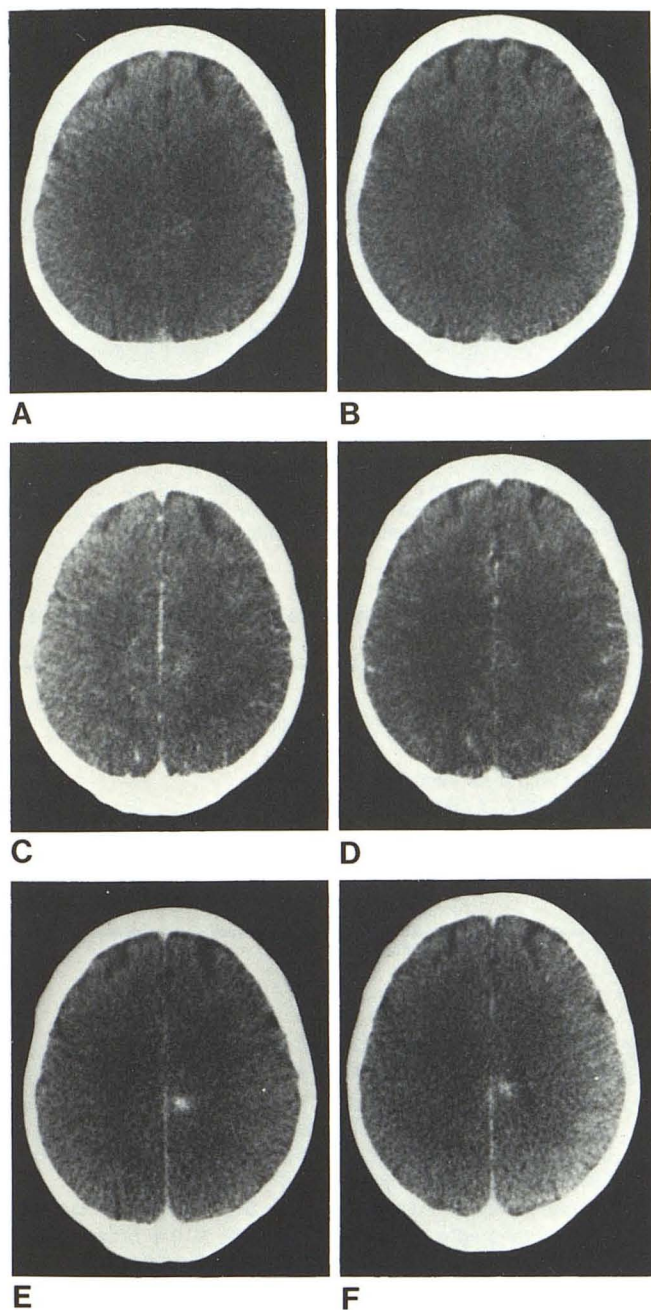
Category 2 lesion. Normal precontrast (A and B) and immediate (C and D) contrast CT. Delayed high dose contrast CT (E and F) shows arteriovenous malformation which was removed from left medial parietal cortex. Pathologic examination revealed thrombosis of vessels. Angiography with stereo magnified subtracted films of all cerebral vessels was normal.
